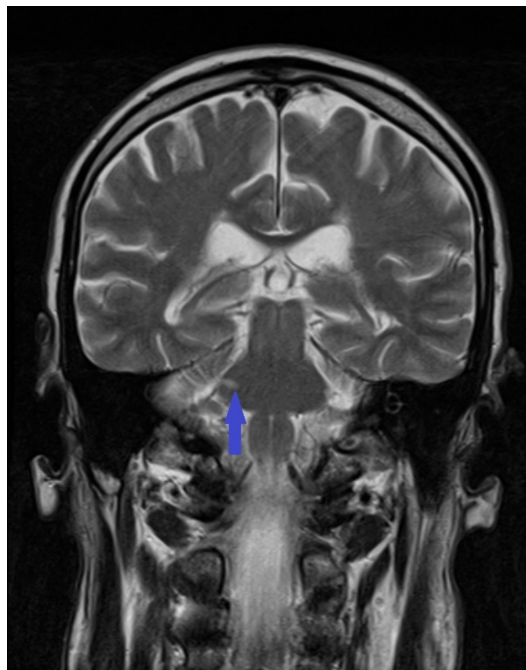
Coronal T2 MRI of the brain showing a new small ovoid focus of hyperintensity in the right side of the pons (arrow).
